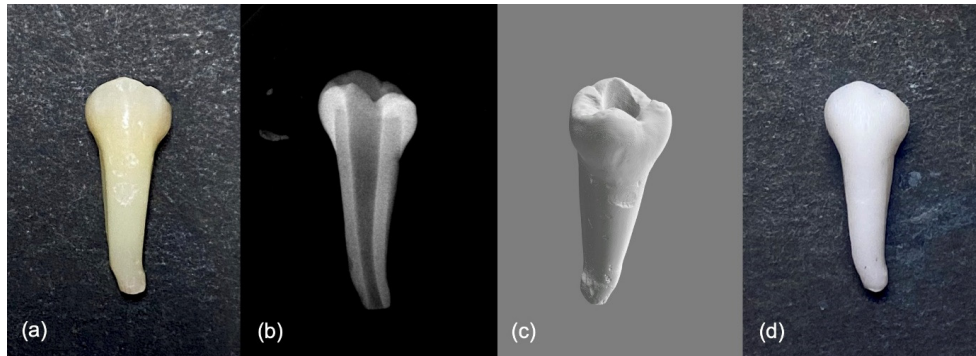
Fabrication process of the resin open apex tooth model: (a) immature tooth model, (b) radiographic image, (c) STL file, and (d) 3D-printed resin open apex tooth model.
